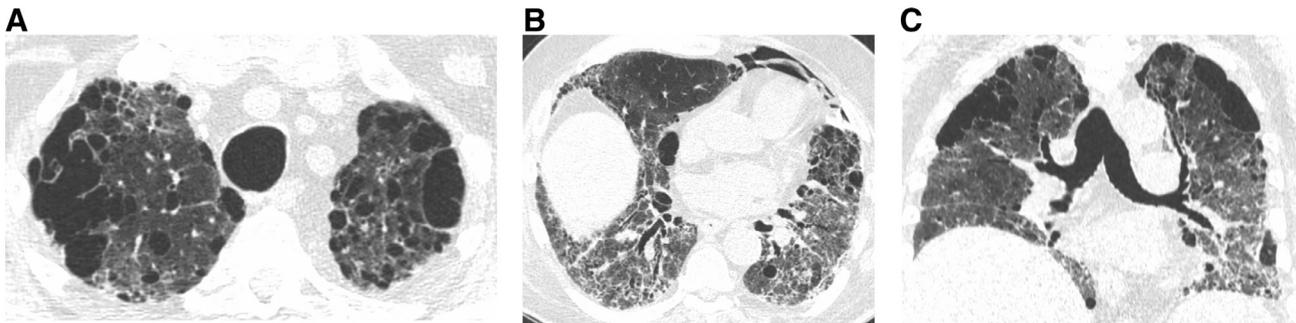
A 72-year-old male smoker with combined pulmonary fibrosis and emphysema. Axial (A-B) and coronal reformatted (C) unenhanced CT images show upper lobe predominant emphysema with large bullae and basal predominant fibrosis characterized by reticulation and traction bronchiectasis. Spontaneous pneumomediastinum (*arrow*) had developed without acute symptoms.
